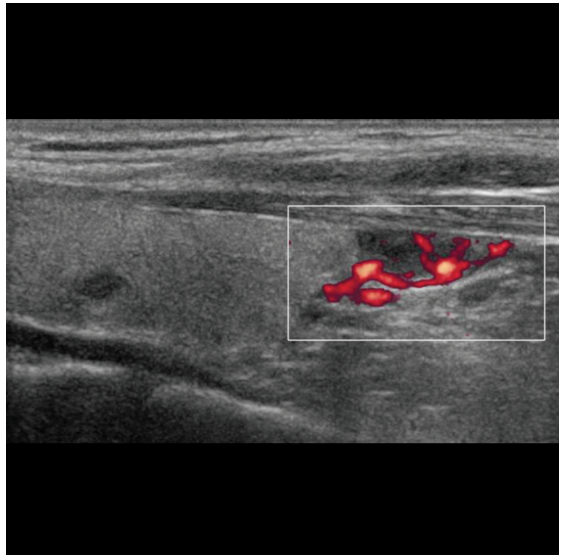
Power doppler image (same patient as above) shows intrinsic hypervascularity within the adenoma.
